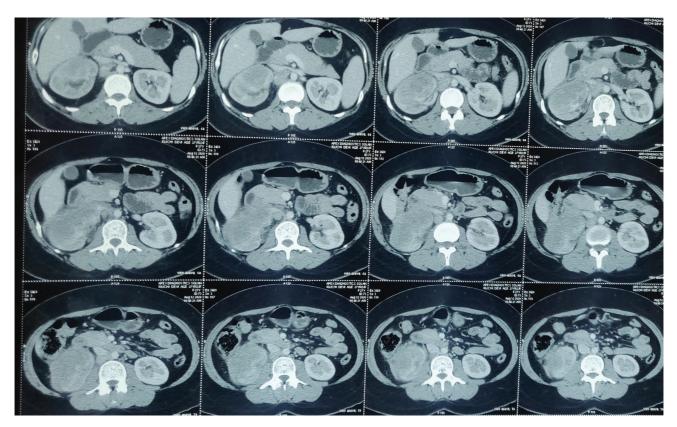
Axial contrast-enhanced computed tomography scan showing ill-defined heterogeneous mass occupying in mid and lower pole of the right kidney with perinephric stranding.
